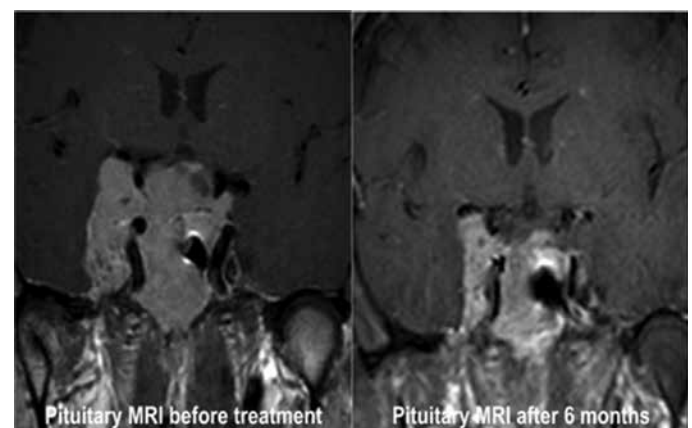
Magnetic Resonance imaging of pituitary gland adenoma of the patient, before and 6 months after treatment
